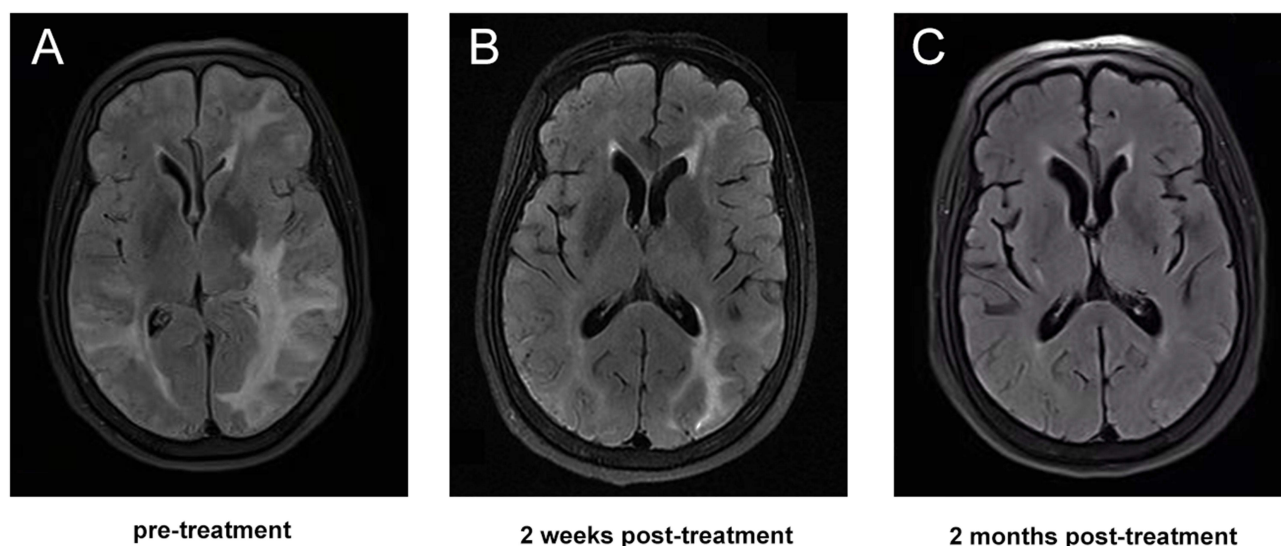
Radiological progression in a representative CAA-ri patient. MRI findings in a 62-year-old woman (patient NO.1) at pre- and post-treatment time points. (A) Initial T2/FLAIR imaging revealed marked asymmetric patchy hyperintensities in both cerebral hemispheres. (B) At 2 weeks after corticosteroid treatment, FLAIR abnormalities decreased. (C) Two months later, follow-up imaging showed further regression of the abnormal lesions.
